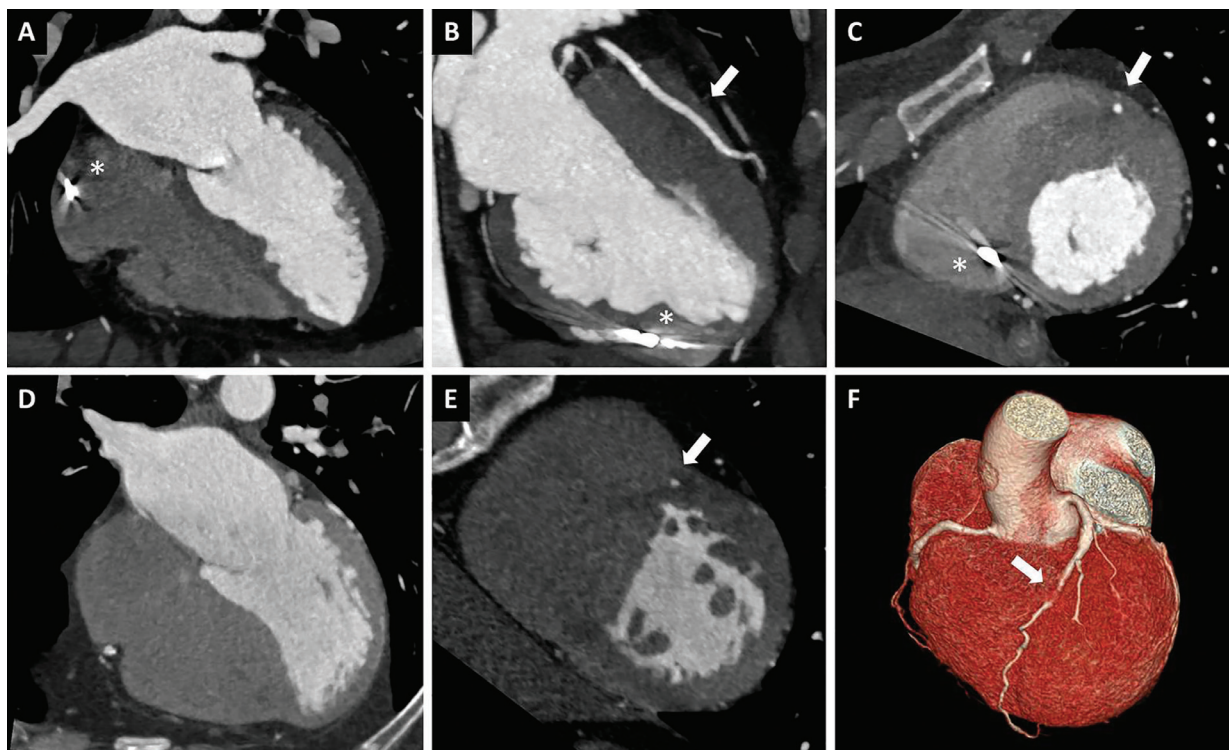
Examples of myocardial bridging on cardiac Coronary Computed Tomography Angiography in HC patients.
